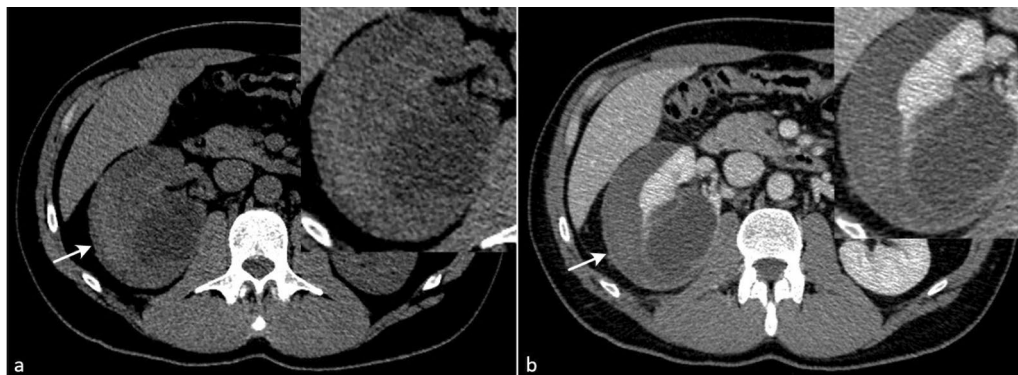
CT showing a large hematoma (arrow) surrounded by Gerota’s fascia in the perirenal space. a Pre-contrast sequences showing the cystic mass surrounded by a hyperdense haematoma in the perirenal space. b Portal venous phase in CT showing Gerota’s fascia enclosing the fluid collection
